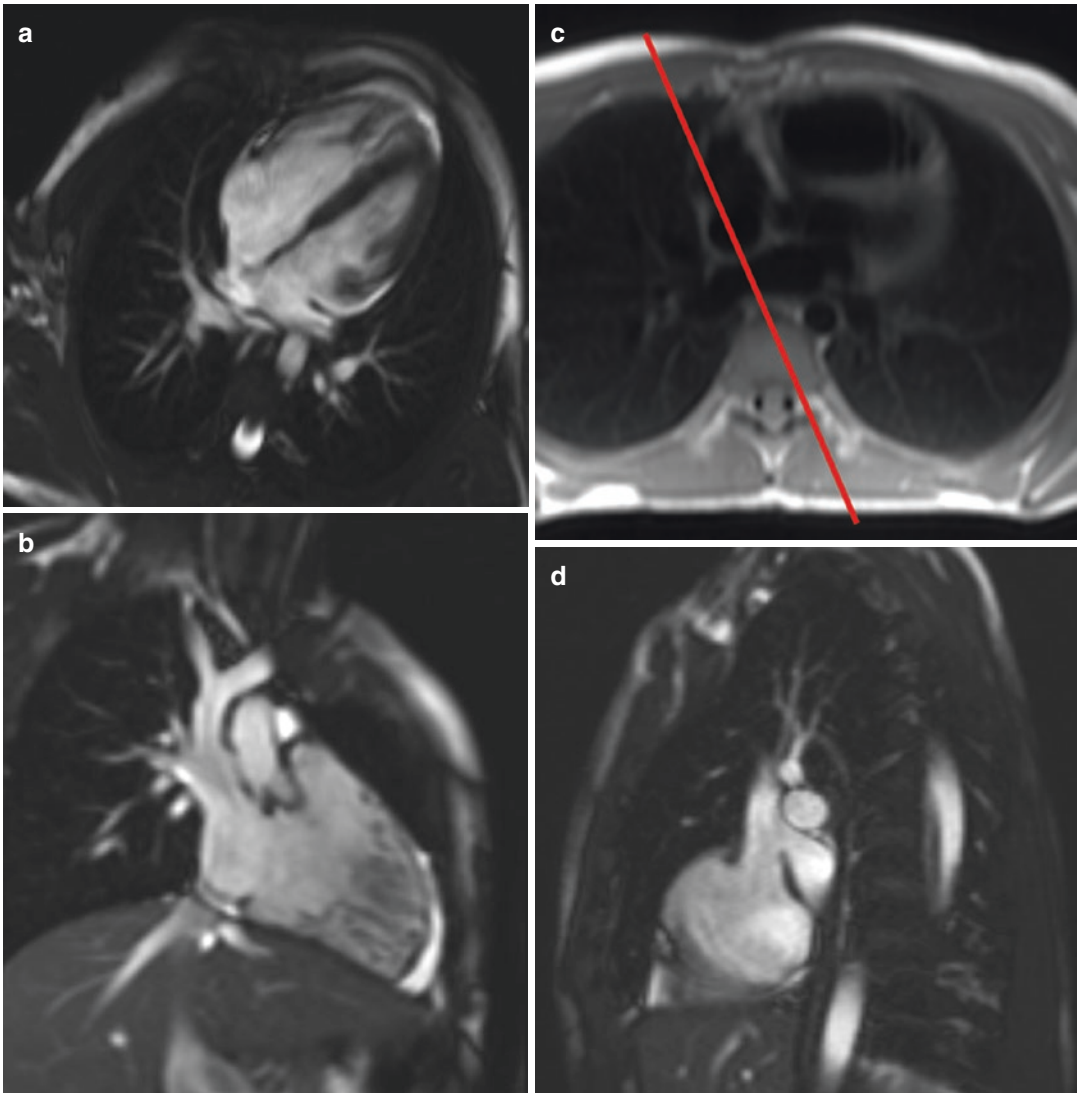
Superior sinus venosus atrial septal defect. (a) Four-chamber view image obtained from cine TRUFISP MRI sequence shows superior type sinus venosus defect located in the posterior and superior aspect of atrial septum at the opening of right superior vena cava. (b) Coronal-view image obtained from cine TRUFISP MRI sequence demonstrates a partial anomalous pulmonary venous return. Blood from the right superior and middle pulmonary veins
